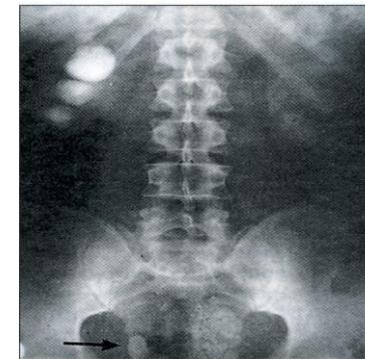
Plain X-ray of the kidney, ureter and bladder (KUB) is a useful initial investigation in many patients. Here it has revealed a rather unusual combination of calculi in both kidneys (more prominent on the right), in the lower right ureter (arrowed) and in a bladder diverticulum.
